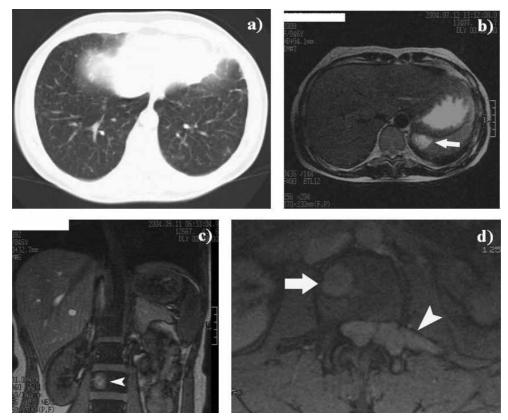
a) Computed tomography scan of the chest shows multiple bilateral nodules of varying sizes; b) Abdominal MRI: axial T2-weighted image demonstrates focal splenic lesion with high signal intensity (arrow); c) Abdominal MRI: coronal T2-weighted image (gradient-echo) of the abdomen delineates area of high signal intensity in the body of L3 vertebrae (arrowhead); d) Axial T2-weighted image (gradient-echo) of the L3 vertebrae reveals hyperintense lesions in the right part of the body (arrow) and left articular and transverse process (arrowhead).
